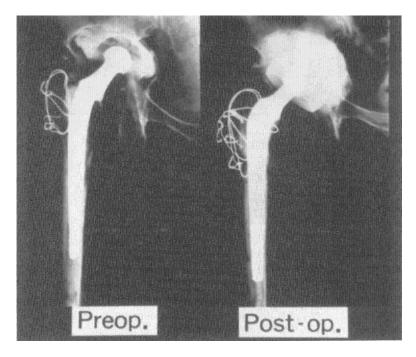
Radiographs of a hip prosthesis revision in a 55 year old female patient.
